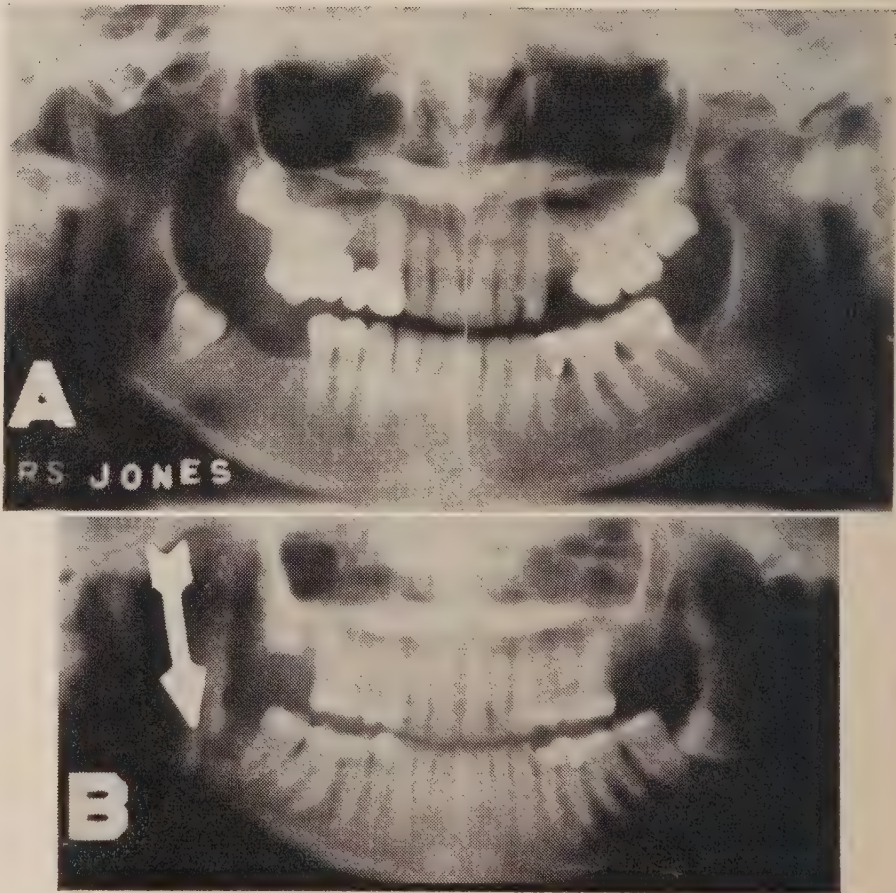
A, Young adult with Class III malocclusion, missing teeth, temporomandibular disturbance and impacted third molars on the right side. All aspects of the problem are seen on a single panoramic view, and the surgeon has a precise outline of mandibular morphology in event he wishes to perform a resection. B, Comminuted mandibular fracture, radiographed without patient opening the mouth. The extent of surgical challenge is readily apparent.
